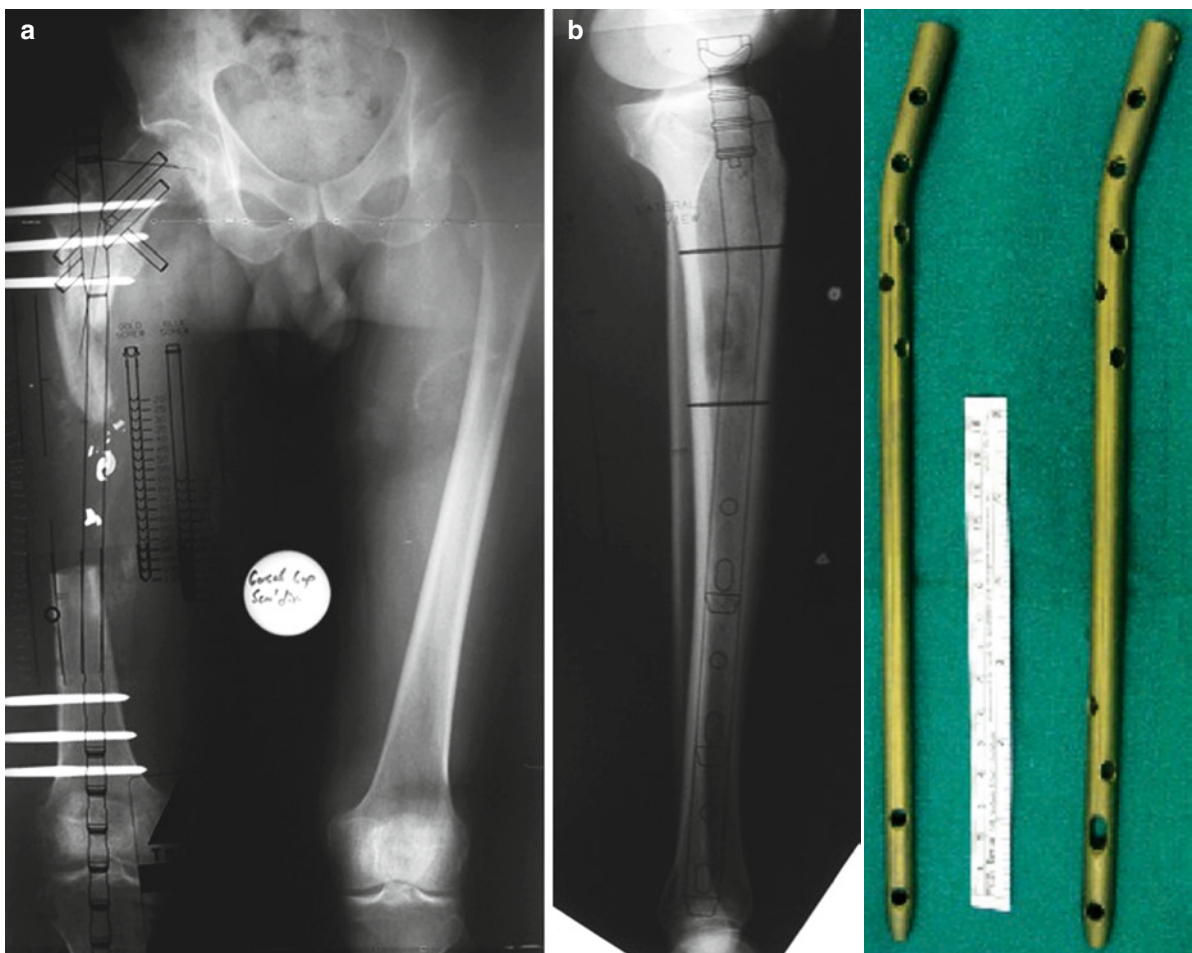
Determination of appropriate intramedullary nail length, diameter, and site of additional locking screw holes on x-rays in the femur and tibia (a, b)
